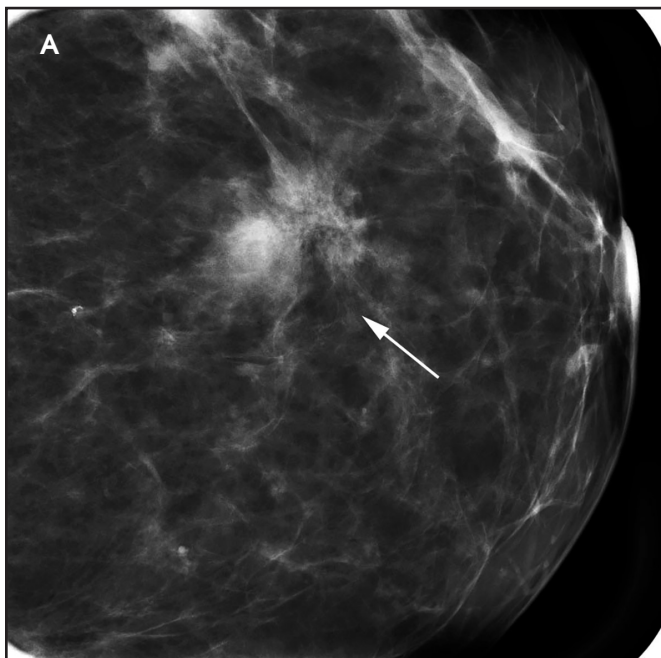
Radial scar/complex sclerosing lesion. (A) 36-year-old woman, with family history of cancer, presented for a screening mammogram, which showed an area of architectural distortion in the left upper medial breast (arrow). Ultrasound evaluation showed a vague hypoechoic taller than wide mass (not shown). Ultrasound-guided core biopsy was performed which showed a radial scar. (B) A 37-year-old woman presented for a high-risk screening MRI that showed an area of architectural distortion in the left breast with non-mass-like enhancement and mixed Type-II and III kinetics (arrows). MRI-guided core biopsy showed a complex sclerosing lesion.
